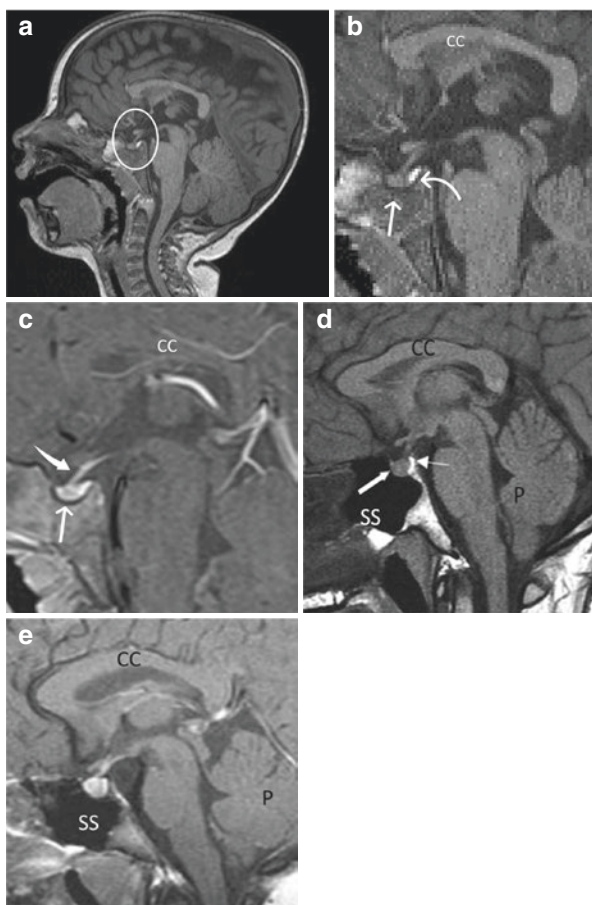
Normal appearance of pituitary gland on MRI. (a) Sagittal T1 images through the brain in a 2-year-old boy with white circle marking the area of the sella and the pituitary gland. (b) Magnified unenhanced sagittal T1 image demonstrating the pituitary gland (straight arrow) and posterior pituitary bright spot of the neurohypophysis (curved arrow). (c) Postcontrast sagittal T1 image shows homogeneously enhancing pituitary gland (straight arrow) with normal enhancing pituitary stalk/infundibulum (thick white arrow). (d) Unenhanced T1 sagittal and (e) postcontrast T1 sagittal through the pituitary gland in a pubertal 13-year-old female demonstrating the pituitary gland (straight arrow) and posterior pituitary bright spot of the thin white arrow) and homogeneous enhancement. CC corpus callosum, SS sphenoid sinus, P cerebellum
